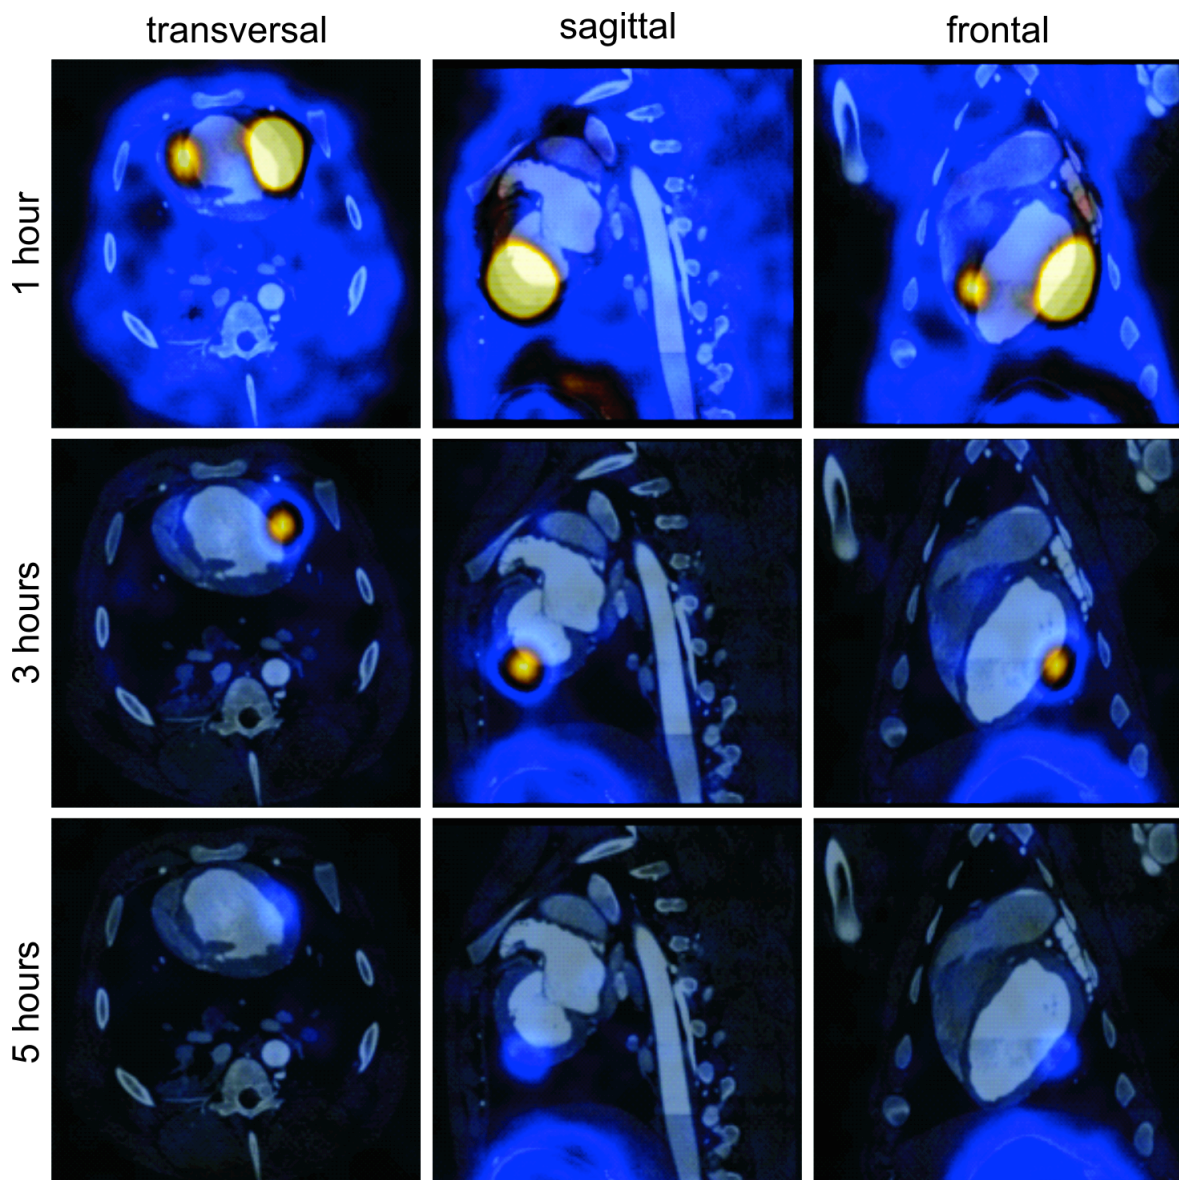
In vivo* Hybrid-SPECT-CT Imaging transplantiertier ¹²³I-markierter NIS⁺-hiPSCs zeigt einen deutlichen Signalverlust innerhalb der ersten 5 Stunden nach Zellapplikation
